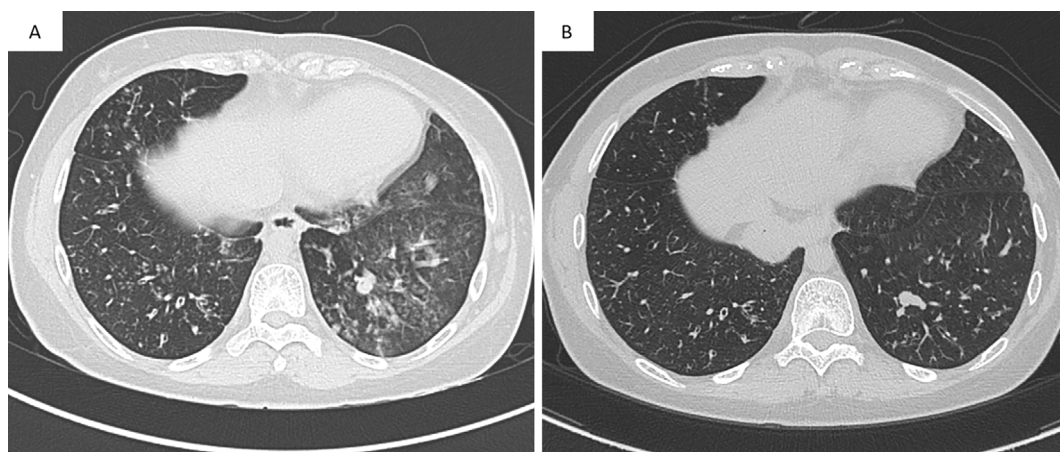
Chest computed tomography images. Before (A) and after (B) the initiation of long-term macrolide therapy.
